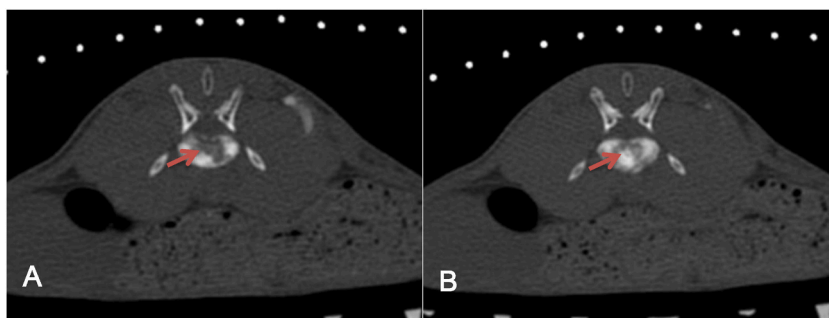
21 days after implantation, CT images of L5 vertebral body VX2 tumor model. A: Irregular bone destruction in the L5 vertebral body and cortical bone destruction at the posterior border of the vertebra (red arrow area); B: Osteogenic changes are seen inside the osteolytic changes (red arrow area). (For interpretation of the references to colour in this figure legend, the reader is referred to the Web version of this article.)
